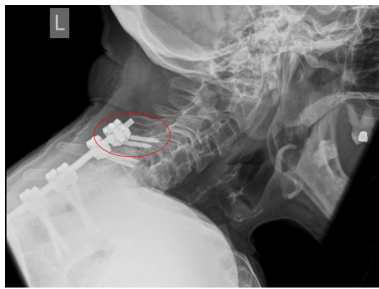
A plain radiograph showing upper screw pull out.
